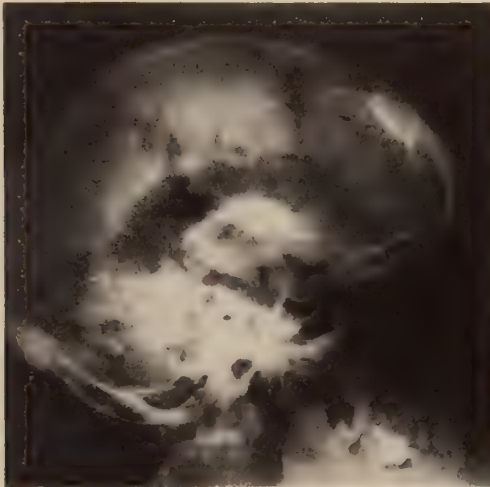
Lateral X-ray picture of the skull following encephalography in Case 1.
